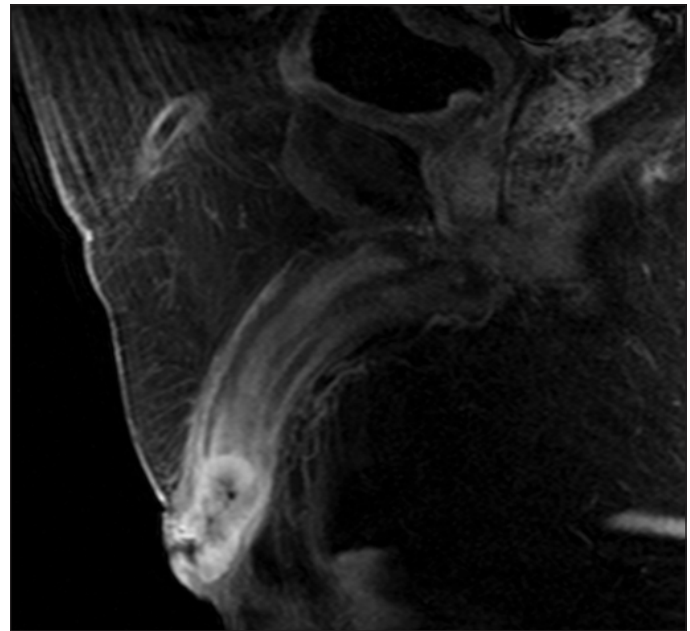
A preoperative magnetic resonance imaging showing a mass centred in the glans penis causing urethral obstruction.
